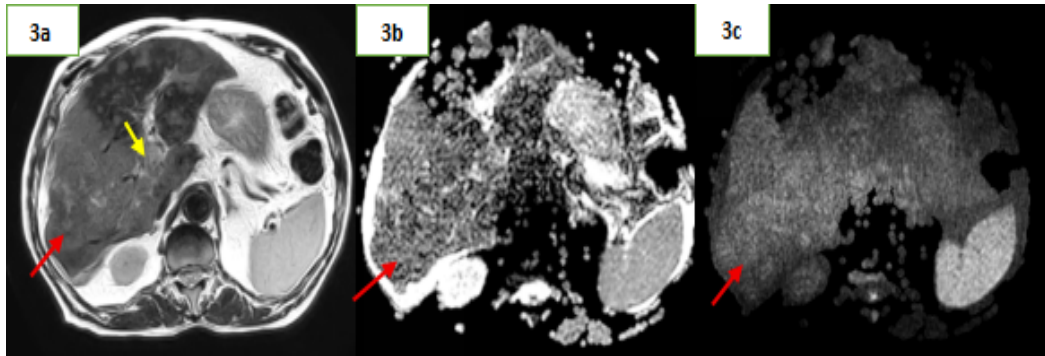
Non contrast MRI upper abdomen in a patient with acute kidney injury– There is a ill-defined T2 heterointense infiltrative space occupying lesion (red arrow) noted in segment VI of liver with corresponding diffusion restriction and associated tumor thrombus (yellow arrow) in the portal vein – likely infiltrative hepatocellular carcinoma
